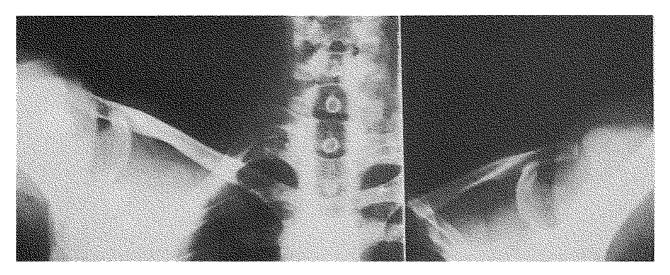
Xray taken on admission, showing bilateral luxatio erecta humeri.
